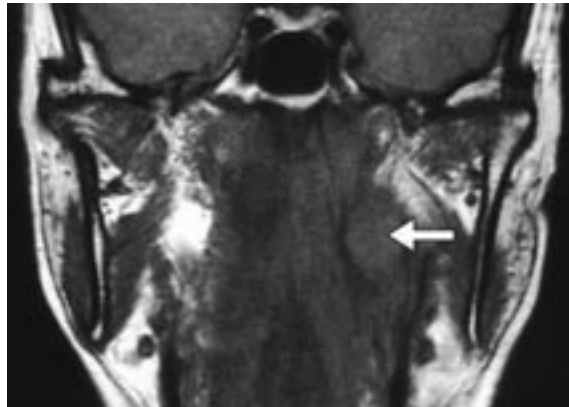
Coronal T1-weighted MR image shows the enlarged left superior cervical sympathetic ganglion (SCSG) (arrow) with low signal intensity.
